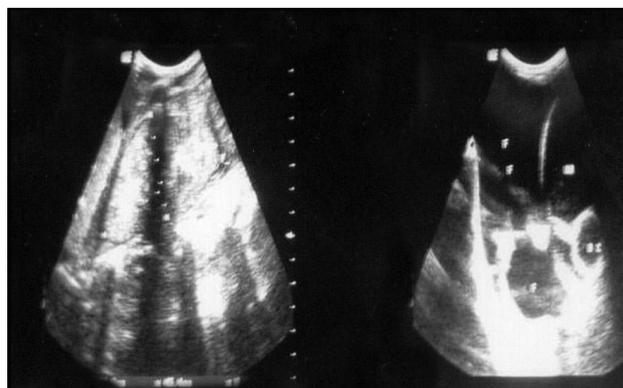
Ultrasound of abdomen showing free fluid.
